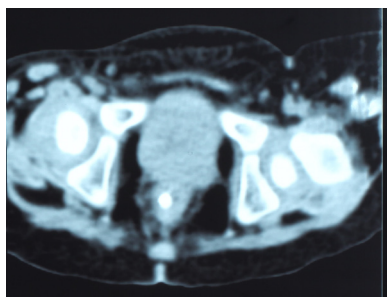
Abdomen computed tomographic scan showing the peritoneal catheter perforating the sigmoid colon.
